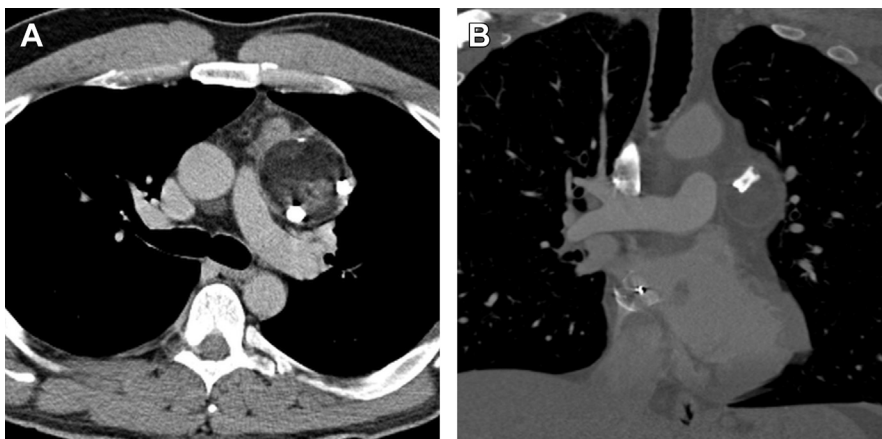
Mature teratoma. (A) Contrast-enhanced axial CT shows a well-defined left prevascular mediastinal mass with intrinsic fat, soft tissue, and densely calcified/ossified components. (B) Contrast-enhanced coronal CT (bone window) shows a calcified structure within the mass that represented a well-formed tooth.
